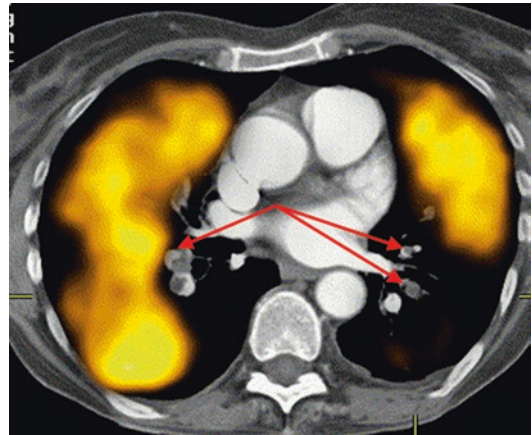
Co-registered CTPA/perfusion SPECT (transverse slice) demonstrating extensive perfusion defects on SPECT corresponding with proximal bilateral PE shown on CTPA (arrowed). (Reprinted with permission from Roach et al. [41])
